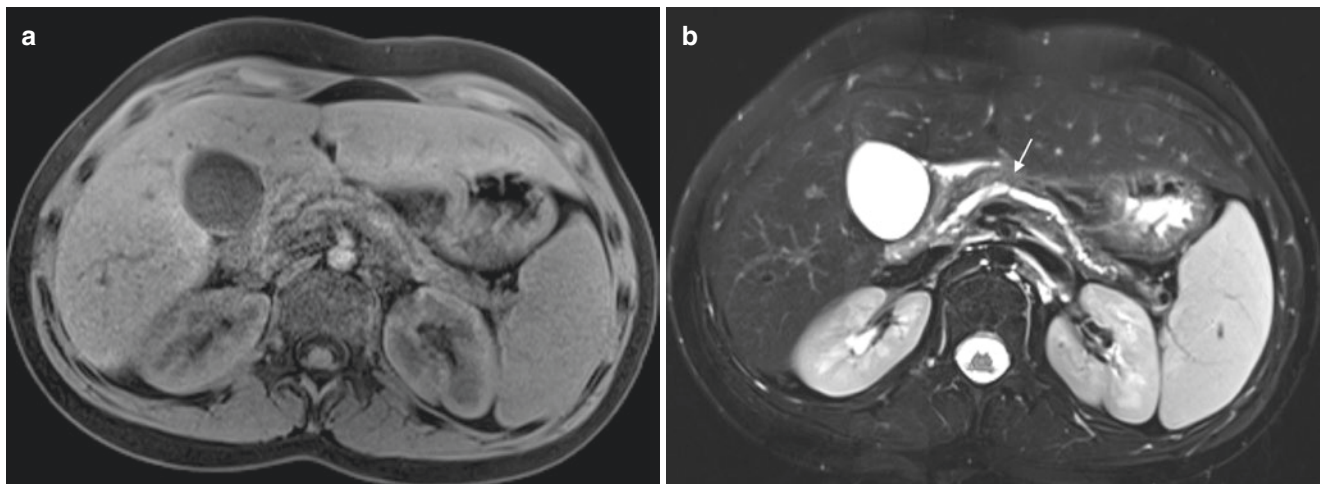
Imaging changes in chronic pancreatitis: Axial (a) T1- and (b) T2-weighted images with fat saturation. The gland is overall atrophic with isointense to mildly hypointense T1 signal relative to the liver. Notice the abnormally distended pancreatic duct with focal stricture (arrow)
